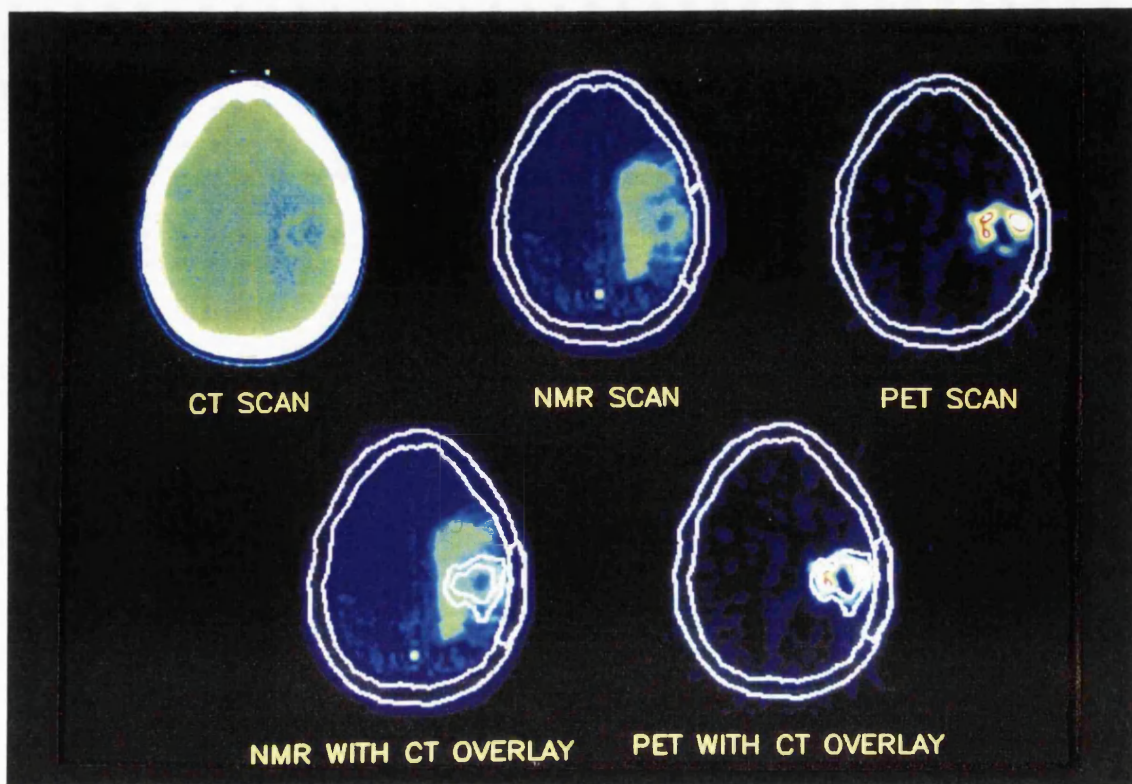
Case 7: Correlated CT, MRI and (F18-FUDR)PET demonstrating recurrence of tumour post craniotomy and radiotherapy
